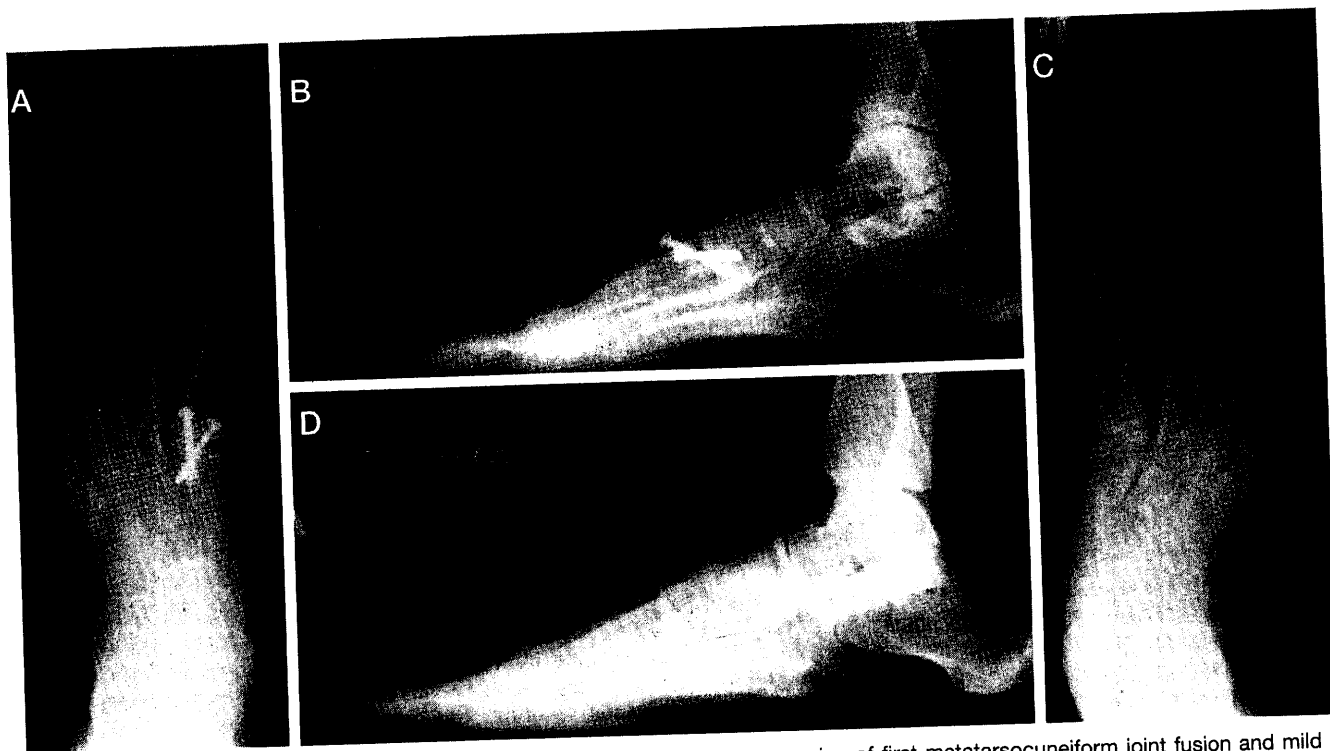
A, Anterior-posterior radiograph of left foot preoperatively. Note non-union of first metatarsocuneiform joint fusion and mild to moderate severity of hallux abducto valgus deformity. B, Lateral radiograph of left foot preoperatively. Elevation of first metatarsal appears to be moderate in severity. Note the lack of fusion of the first metatarsocuneiform joint. C, Anterior-posterior radiograph of right foot. Asymptomatic foot of patient with moderate increase in intermetatarsal angle and mild angulation between first metatarsal and medial cuneiform bones. D, Lateral radiograph of right foot. Note no elevated status of first metatarsal.
